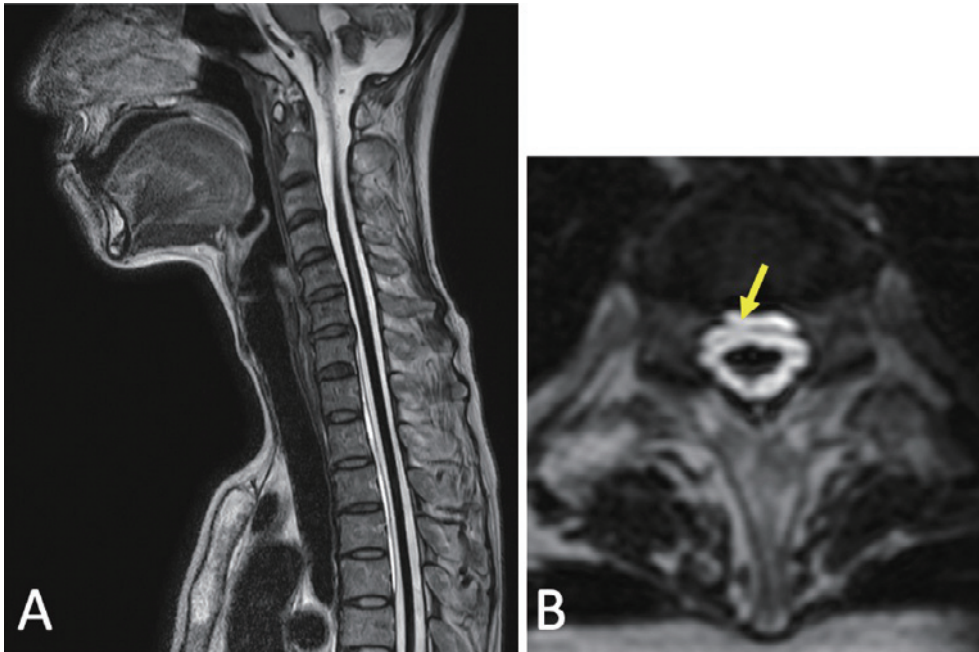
Preoperative CISS MR images of the spine.
